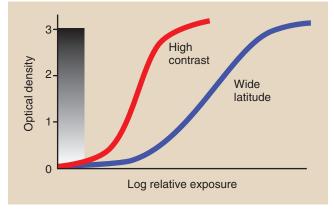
The contrast of a radiographic image can be somewhat controlled, but the visual range remains at approximately 30 shades of gray.
